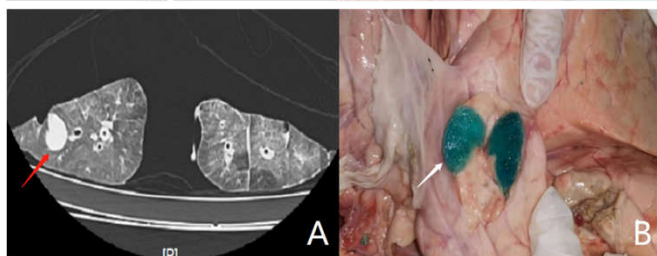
A peripheral artificial tumor target about 20mm in diameter visible by chest CT (Figure 3A, red arrow) was created by inject 3ml solution transthoracically. The picture taken after cutting open the lung was showed in Figure 3B (white arrow)
